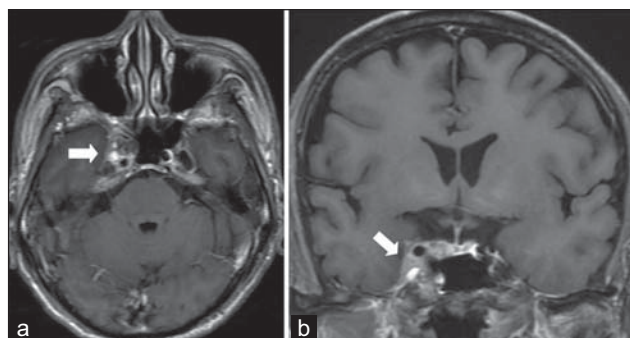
Right cavernous sinus (CS) metastasis from hepatocellular carcinoma. Contrast-enhanced axial (a) and coronal (b) T1-weighted magnetic resonance images showing a lesion involving the right CS (white arrow)
